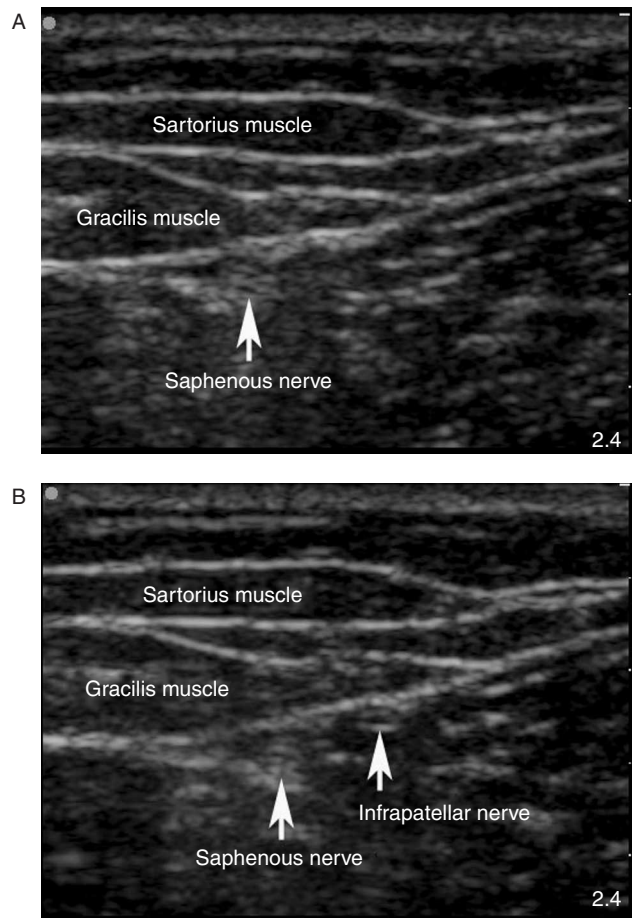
Ultrasonographic pictures of the relevant anatomy. (A) Saphenous nerve, (B) saphenous and infrapatellar nerves.
